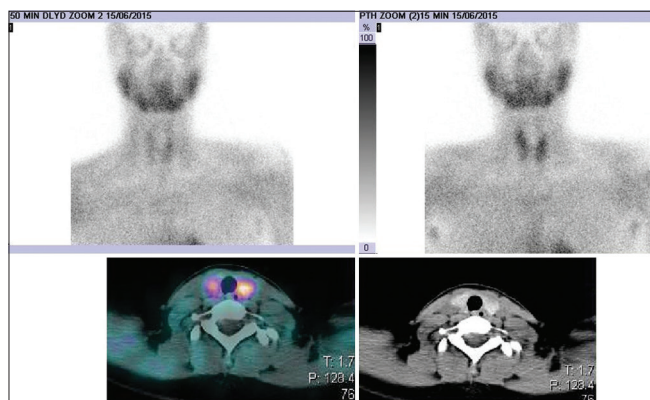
A 30-year-old female with features suggestive of primary hyperparathyroidism. No parathyroid lesion was localized on sestamibi scan with SPECT/CT. SPECT/CT: Single-photon emission computed tomography/computed tomography
